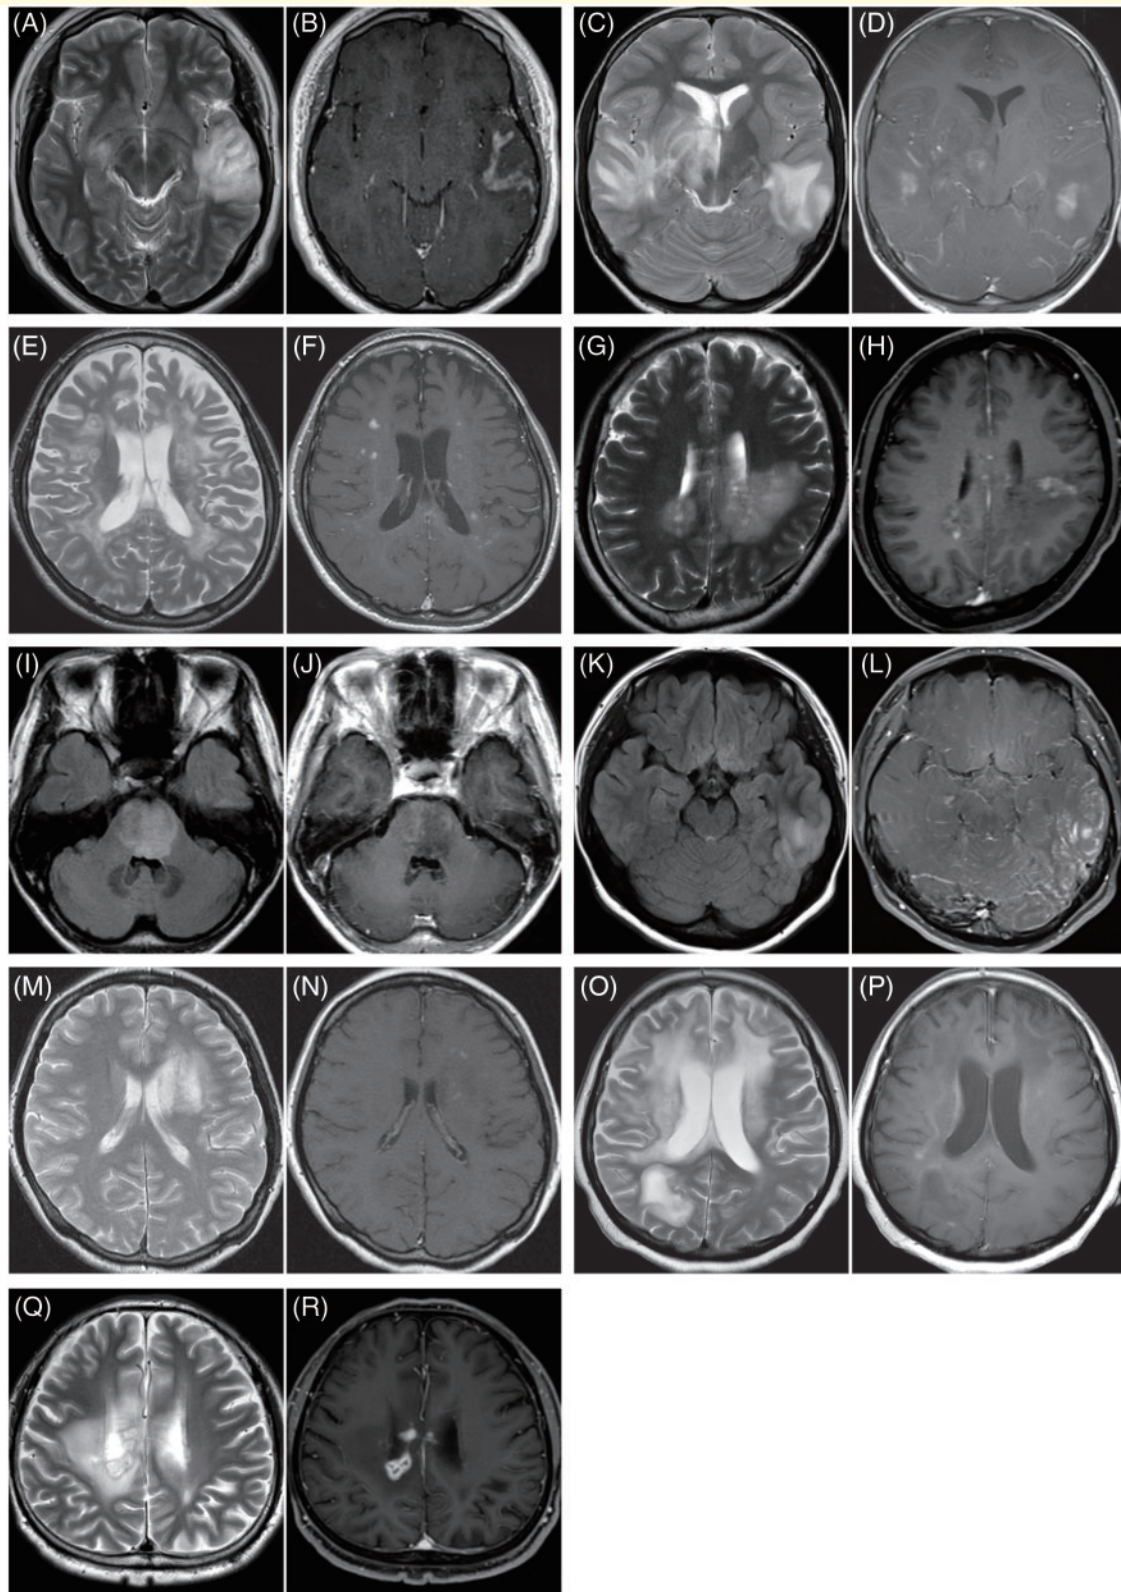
Brain MRI of the patients with MOG antibody-associated disease. (A and B) Patient 1, ADEM. T₂-weighted imaging (T2WI) revealed a large hyperintense lesion extending from the cortex to the subcortical white matter in the left temporal lobe (A). The lesion was Gd-enhanced in the subcortical white matter, but it partially extended into the cortex (B) [T2WI (A); Gd-T1WI (B)]. (C and D) Patient 2, multiple brain lesions. Large T₂-hyperintense lesions were visible in the bilateral temporal lobes with the right-sided lesion extending to the right basal ganglia and thalamus (C). Contrast enhancements were mainly located in the white matter (D) [T2WI (C); Gd-T1WI (D)]. (E and F) Patient 3, leukoencephalopathy. Extensive T₂ hyperintense lesions (E) were localized in the deep cerebral white matter with multiple punctate
